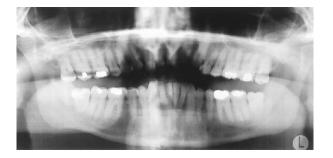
Pretreatment panoramic x-ray.
